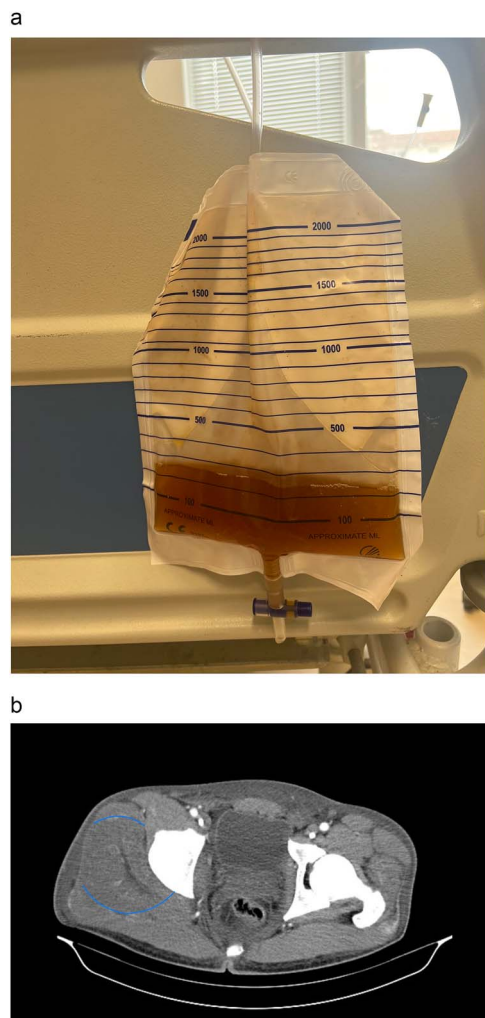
(a) Patient's urine sample. (b) CT scan of pelvis, axial view showing regional oedema in the right gluteal muscle, indicated by the blue circle.
